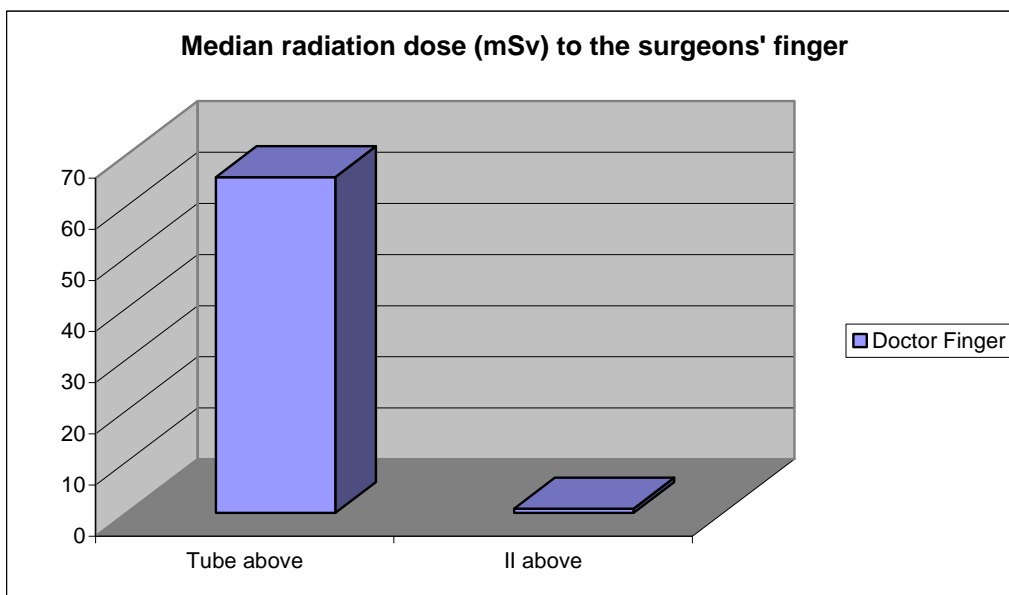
The finger dose values of the neurosurgeons with the x-ray tube and II respectively above the table
